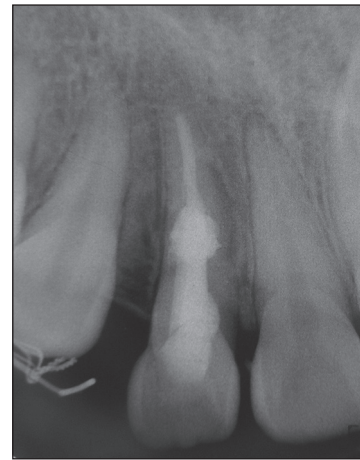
Periapical view of the tooth 3 years after
